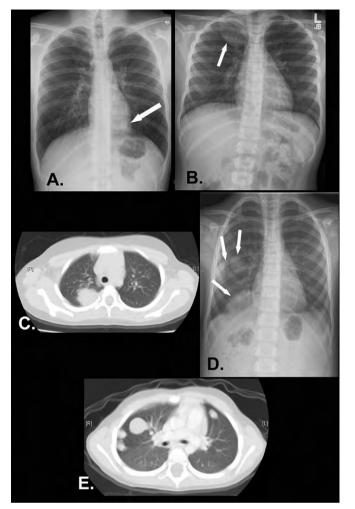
Radiographs of pulmonary parenchymal lesions. A, A 1.7cm solitary pulmonary nodule seen on a chest radiograph in an 18-year-old man, ultimately diagnosed with a rare and benign pulmonary sclerosing hemangioma. A single metastatic lesion from a Wilms tumor in an 8-yearold seen on a chest radiograph (B) and a computed tomography scan of the chest (C). Multiple metastatic Wilms tumor lesions in a 5-year-old seen on chest radiograph (D) and a computed tomography scan of the chest (E).
